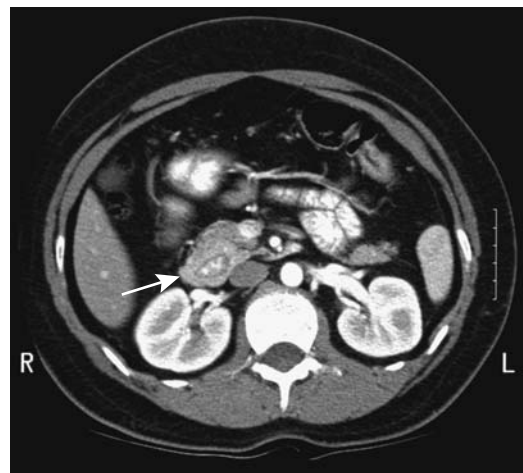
Annular pancreas. After oral and IV contrast CT shows the pancreas surrounding descending duodenum (arrow).
